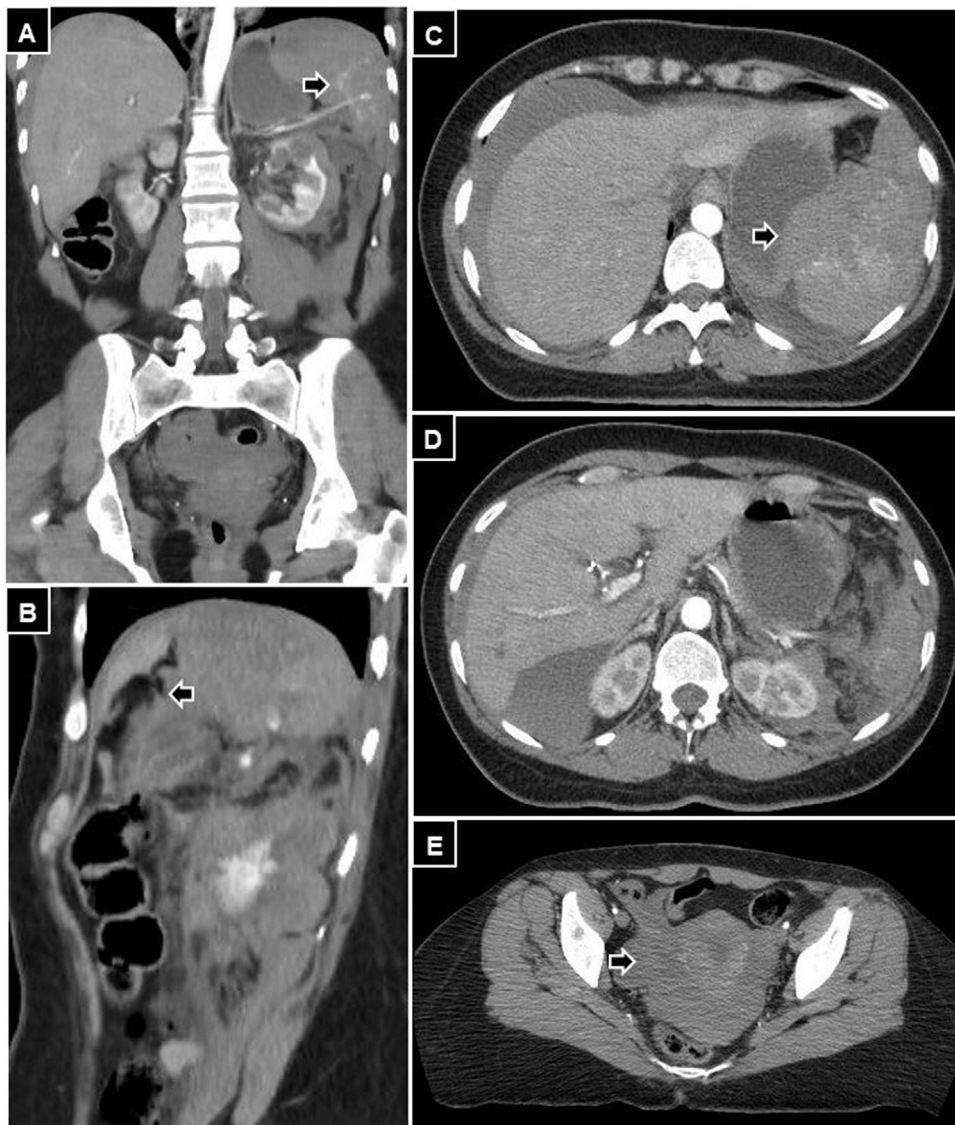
Computed tomography of the abdomen and pelvis. A: Contrast extravasation (arrow). B: Parenchymal laceration (arrow). C: Hypodense subcapsular mass (arrow). D: Perihepatic and perisplenic free fluid. E: Hemoperitoneum in the pouch of Douglas (arrow).
